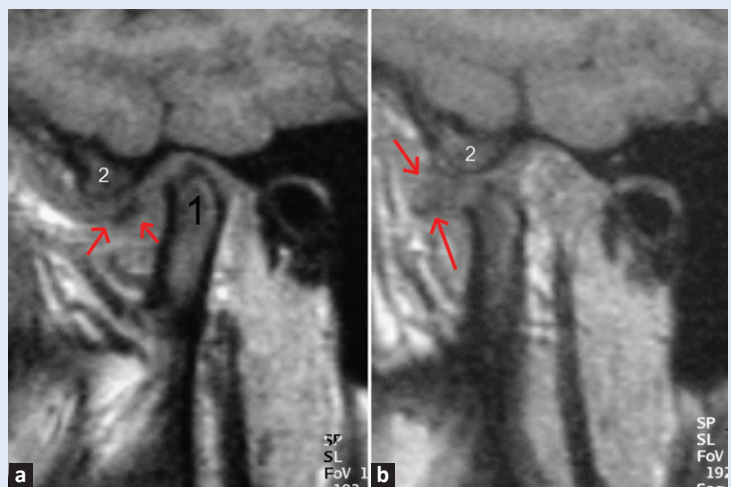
MRI of the right TMJ
